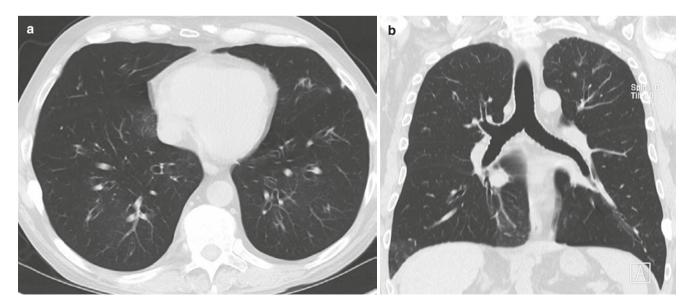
A 46-year-old man with small and large airways disease from ulcerative colitis that flared after colectomy. (a, b) Axial and coronal CT images show bronchiectasis, mosaic attenuation, overinflated lungs, and the paucity of bronchovascular markings (obliterative bronchiolitis)
